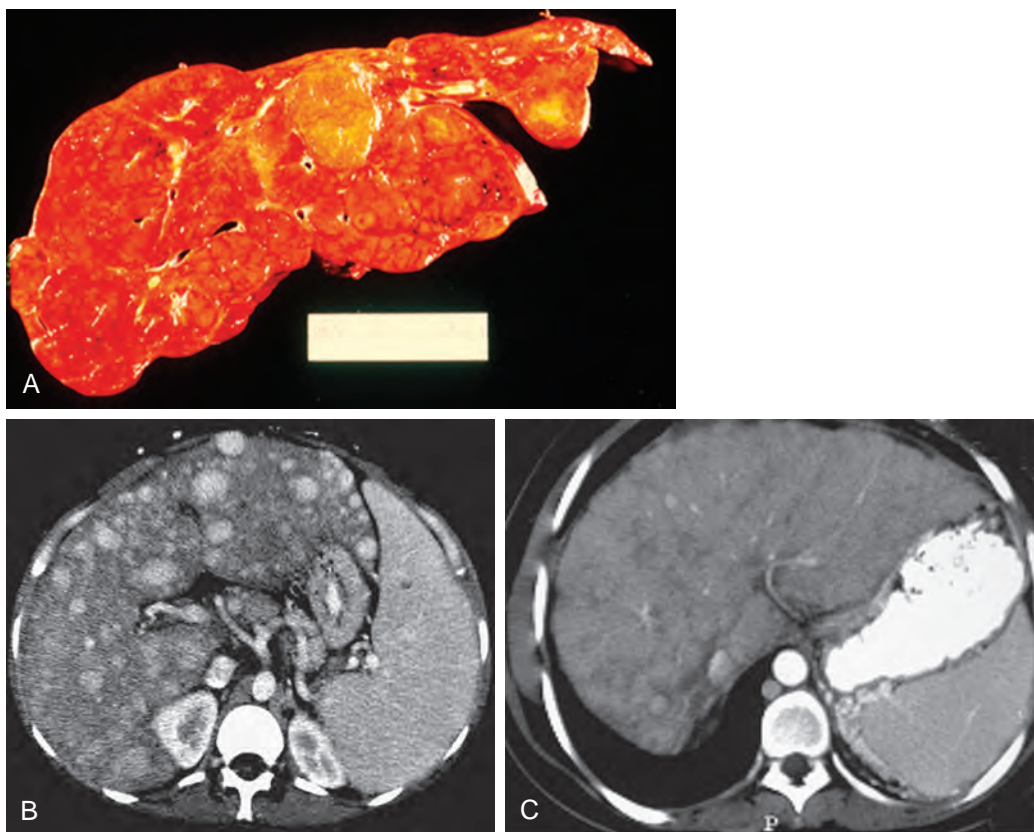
Nodular regenerative hyperplasia. A. This rare condition is characterized by small regenerative nodules composed of hepatocytes that compress the surrounding parenchyma and are not surrounded by fibrous tissue. This lack of fibrosis differentiates nodular regenerative hyperplasia from cirrhosis. B and C. Multiple robustly enhancing hepatic masses are identified on these contrast-enhanced CT scans in two patients with the Budd-Chiari syndrome. (A and B courtesy Michael P. Federle, MD, Palo Alto, CA.)
